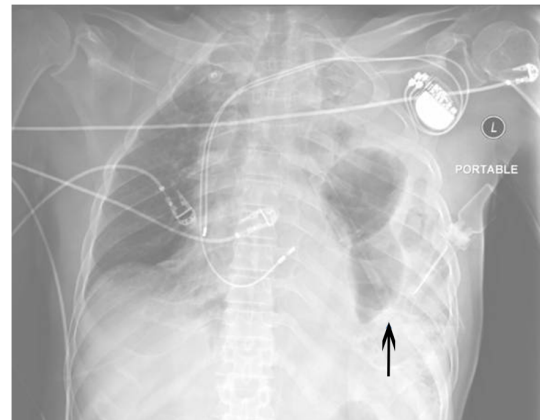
Portable anteroposterior chest x-ray demonstrating left rib fractures, hemothorax and left diaphragmatic rupture (arrow). Biventricular pacer is also noted.
